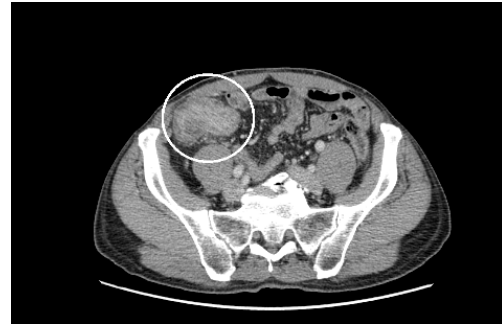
Computed Tomography (CT) scan demonstrating the colonic tumour shown circled.
